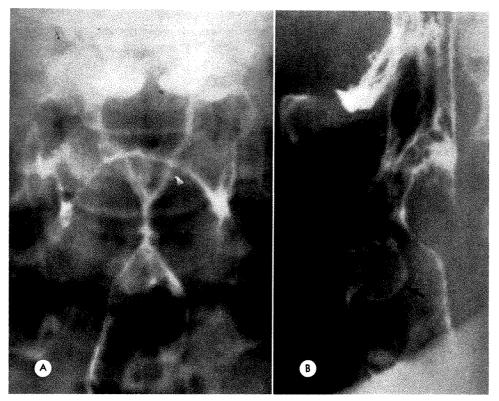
Case 1. (A) Frontal and (B) lateral roentgenograms of positive contrast study. Rounded exophytic mass of the right true vocal cord projecting inferiorly (single arrows). Tumor crossing the midline anteriorly obliterates the anterior portion of the immediate subglottic area (open arrow in B).
